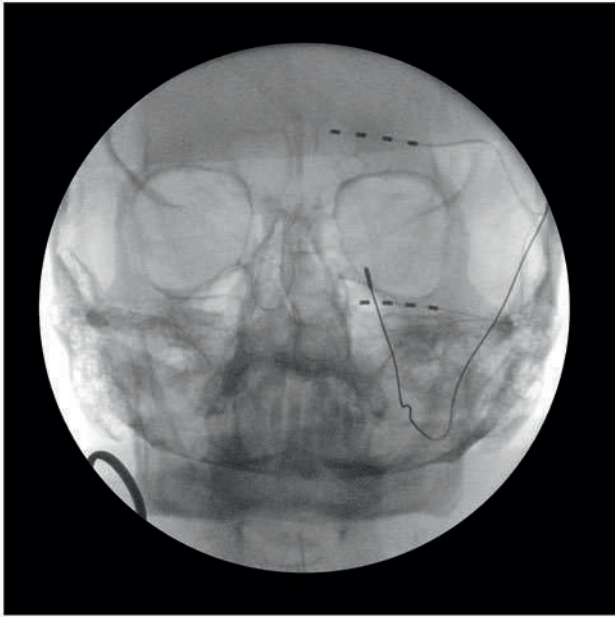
Anterior-posterior radiograph demonstrating placement of supraorbital and infraorbital leads. There is a lead in the foramen ovale as well for stimulation of the trigeminal nerve at that location.
